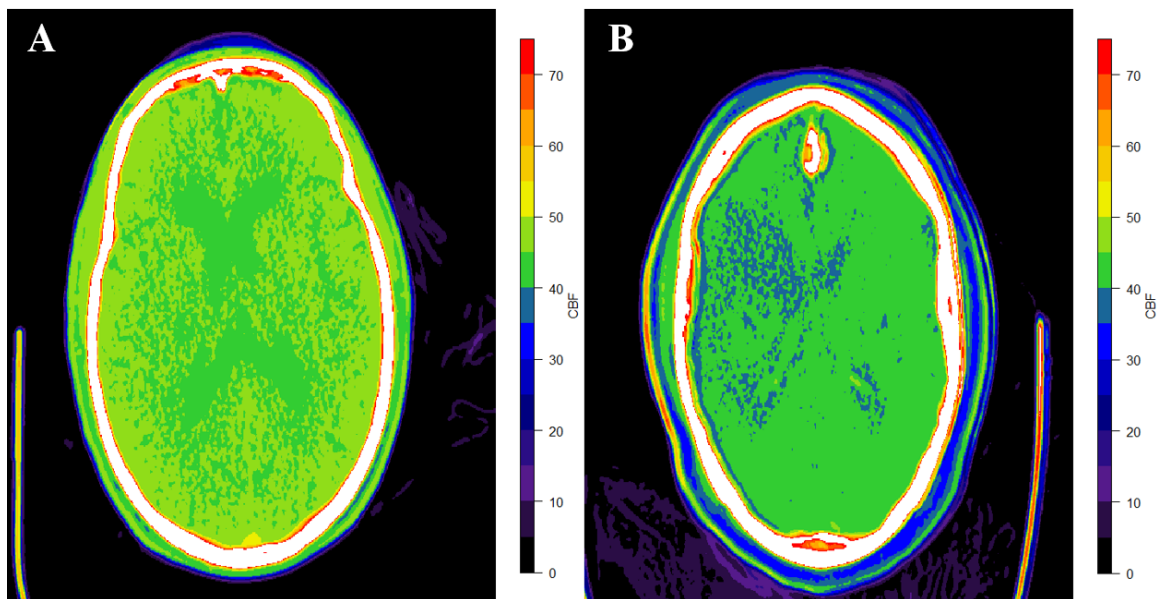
Results from in vivo CTP data. Patient A has normal blood flow as confirmed by no evidence of stroke on MRI. Patient B had a confirmed large vessel stroke located in the anterior cerebral artery.
